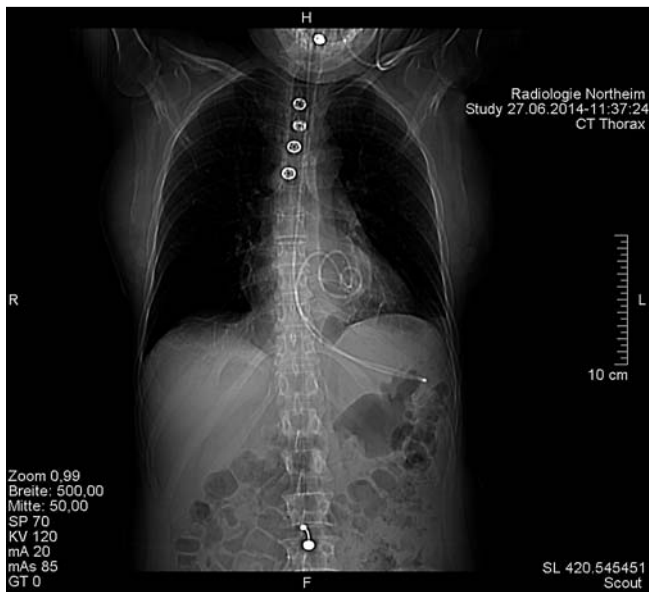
CT Scout view demonstrates the position of the nasocystic drainage.
